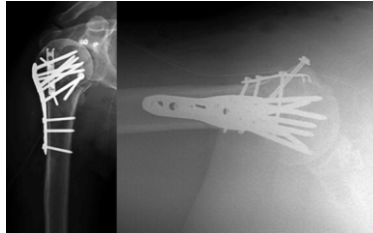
Immediate post-operative radiographs showing fixation of the proximal humerus fracture.
